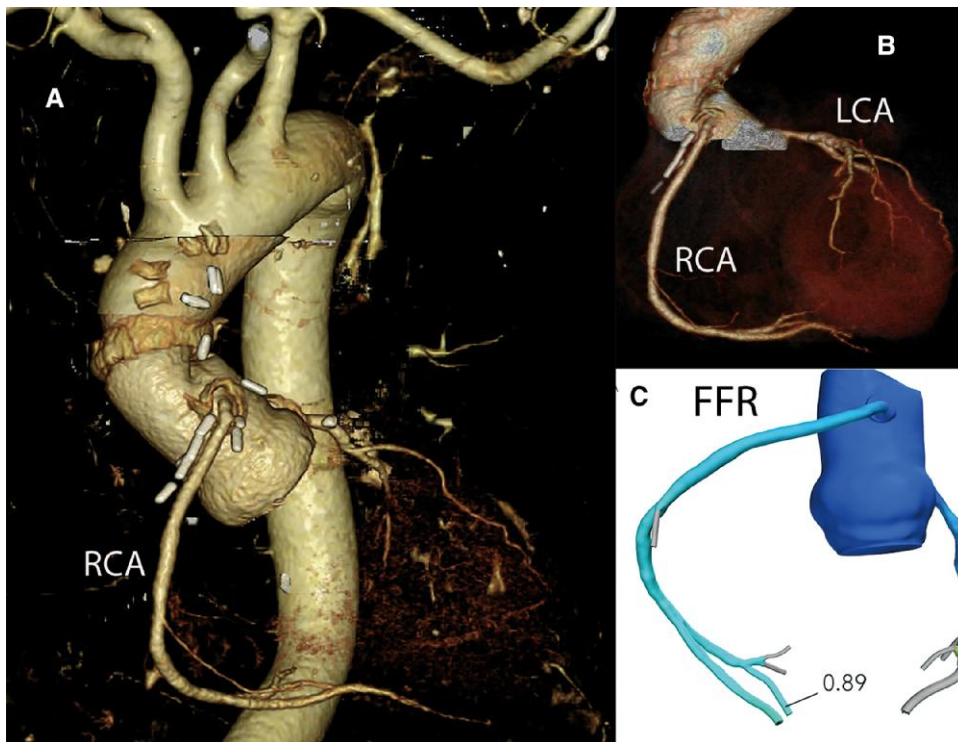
Post-operative enhanced computed tomography images. (A) Three-dimensional reconstruction imaging. (B) Three-dimensional reconstruction of coronary computed tomography angiography: no significant stenosis in the right coronary artery. (C) Fractional flow reserve-computed tomography imaging: without significant decrease in FFR with a value of 0.89 in the distal RCA. FFR, fractional flow reserve; LCA, left coronary artery; RCA, right coronary artery.
